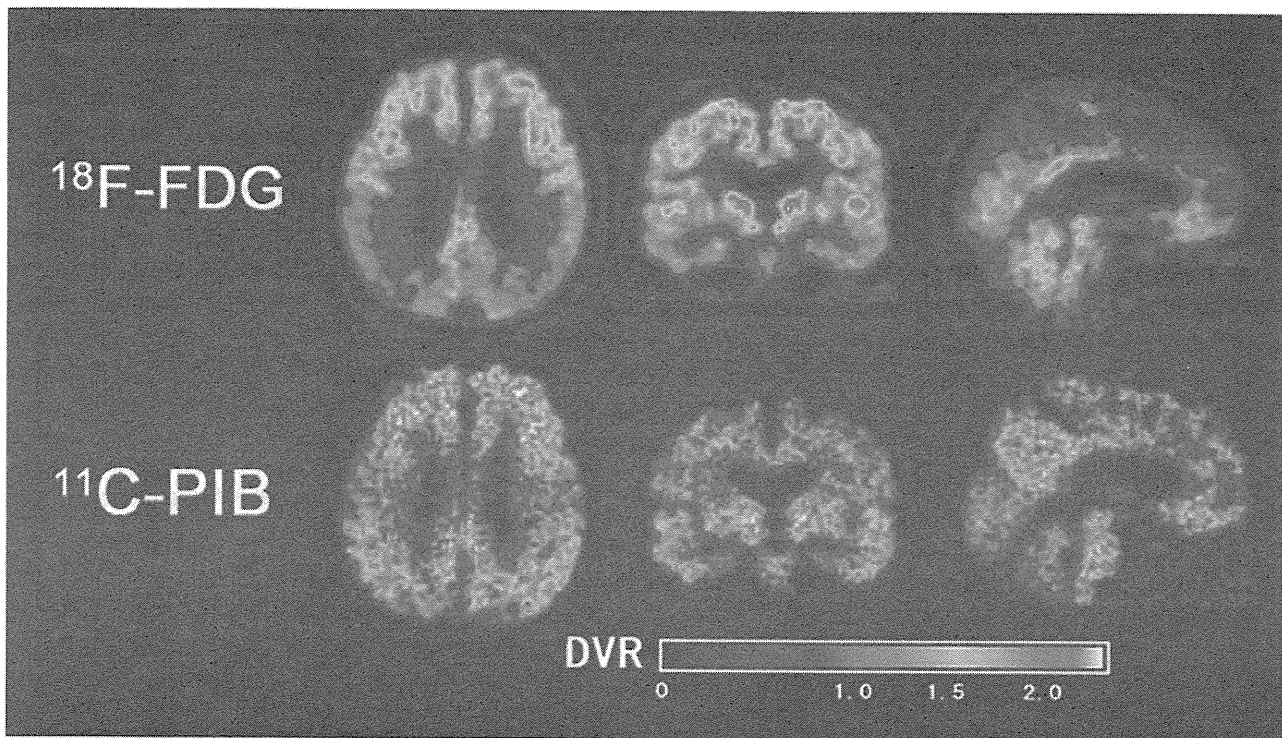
Typical FDG and PiB-PET findings for AD in a 72-year-old male patient. His minimal state examination score was 18. Note high PiB deposition in the prefrontal cortex and posterior cingulate/precuneus, whereas FDG-PET showed decreased glucose metabolism in posterior cingulate/precuneus and bilateral parietal cortex.
